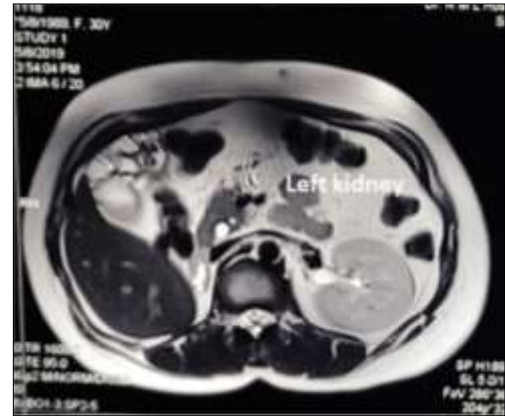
MRI image showing right renal agenesis
